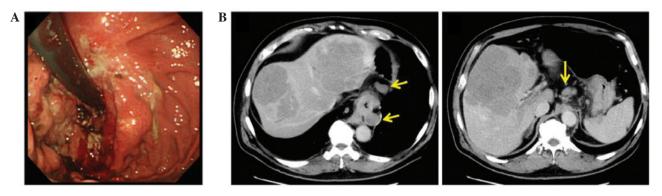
Imaging examinations. (A) Gastrointestinal endoscopy revealed a type 3 lesion in the cardia region. (B) Computed tomography imaging prior to chemotherapy revealed multiple liver and nodal metastases (arrows).
